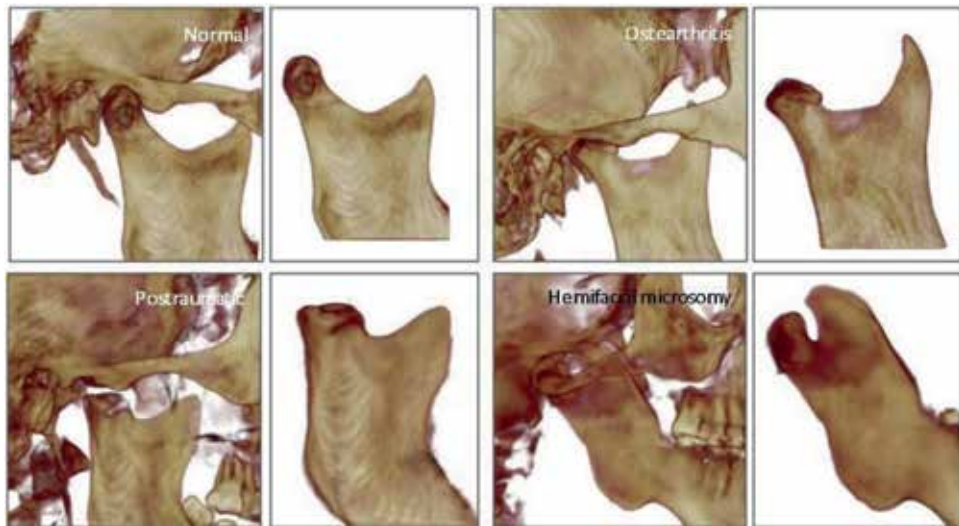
Cone beam CT of the right adult TMJ in normal conditions, osteoarthritis, posttraumatic, and hemifacial microsomia. Images obtained from Instituto Asturiano de Odontología, Oviedo, Spain.
